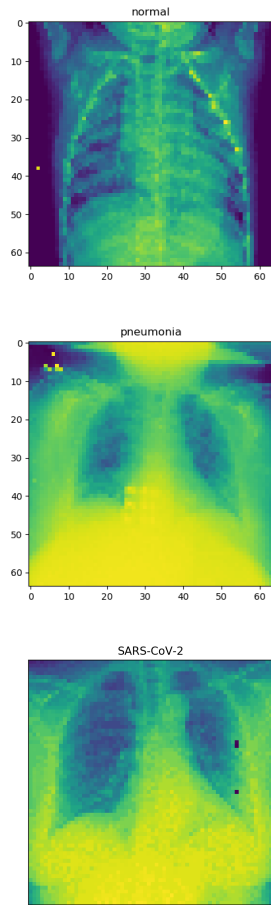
A comparison of our preprocessed images. We have a healthy radiograph (Top-Left), a pneumonia positive radiograph (Top-Right) and a SARS-CoV-2 positive radiograph (Bottom).
